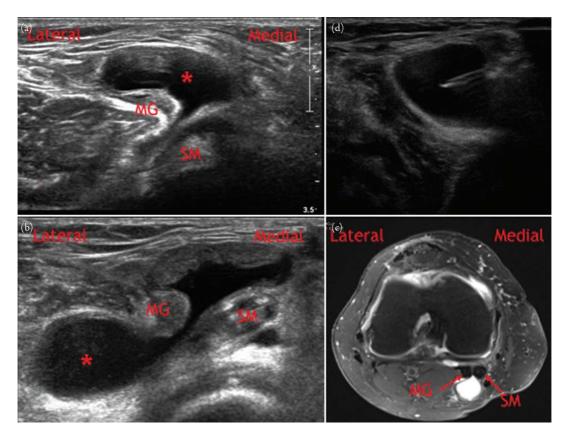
Posterior knee masses. Panels (a) and (b) show transverse planes of the posteromedial knee with hypoechoic fluid (*) extending between the medial head of the gastrocnemius muscle (MG) and the semimembranosus tendon (SM), respectively. This is consistent with a popliteal cyst. Panel (c) shows an axial magnetic resonance imaging fluid sensitive sequence with a popliteal cyst between the medial head of the gastrocnemius muscle (MG) and the semimembranosus tendon (SM). Panel (d) shows a linear echogenic needle tip seen entering a popliteal cyst during percutaneous cyst drainage.
